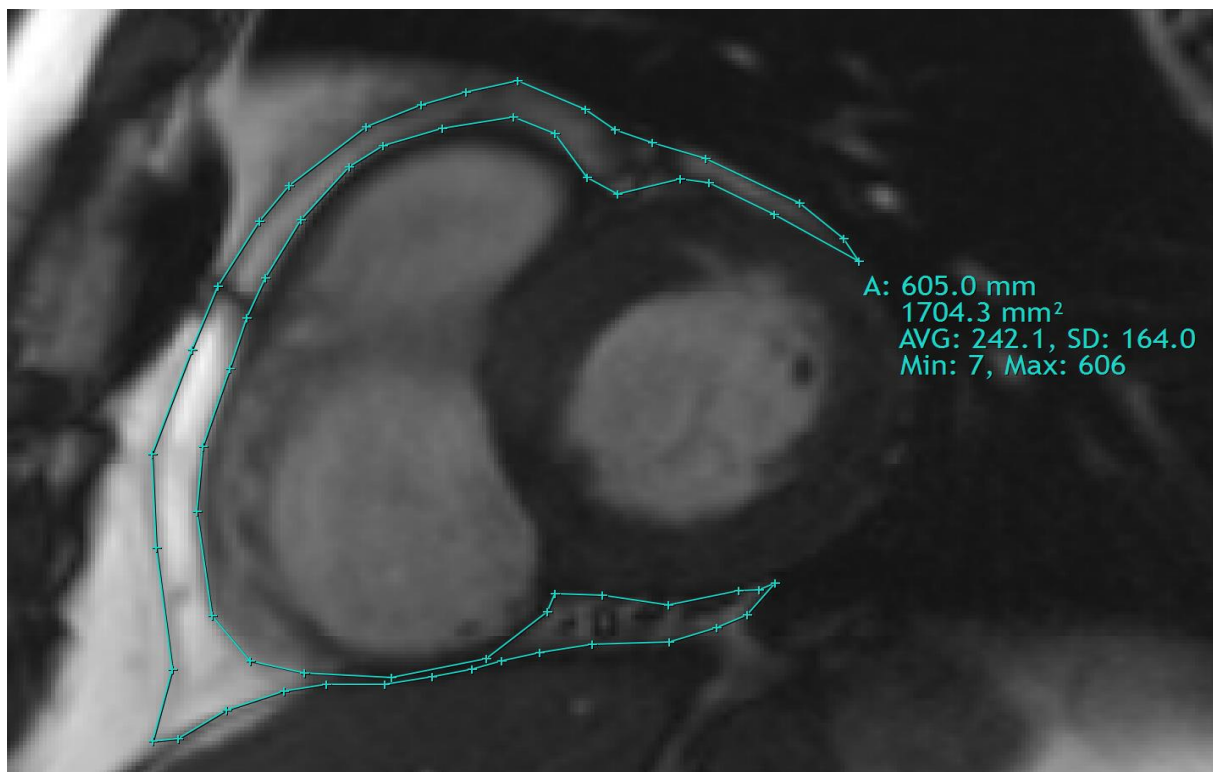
Epicardial adipose tissue area measured on cardiac magnetic resonance image, acquired using the segmented steady state free precession algorithm. Area of the epicardial fat is outlined using area measurement tool. Abbreviations: A – area, AVG – average, Min – minimum, Max – maximum, mm – millimeter, mm<sup>2</sup> – square millimeter, SD – standard deviation
